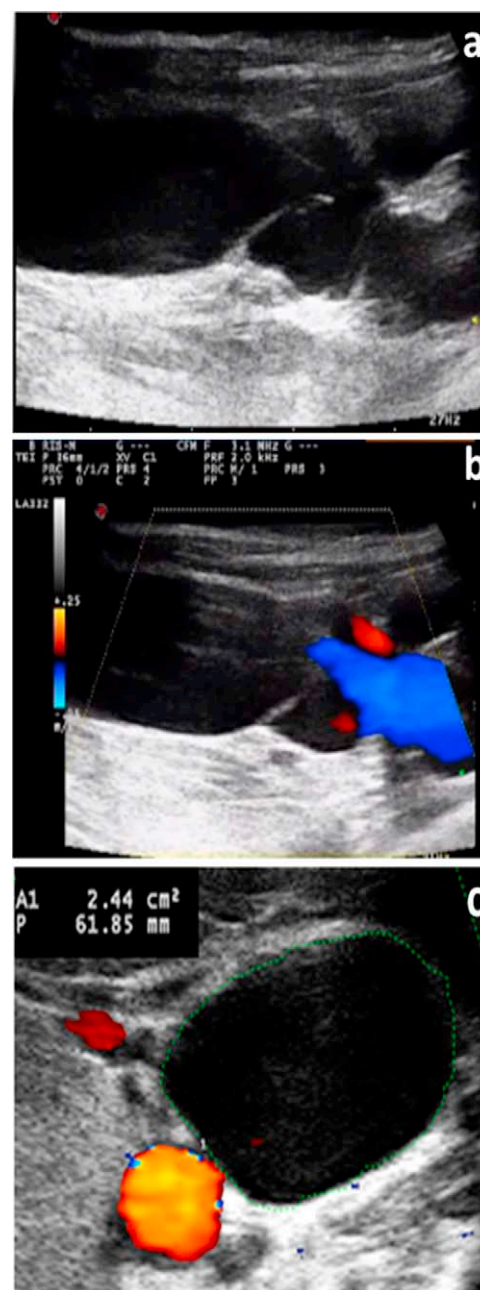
Example of the positivity of criterion 3. (a) B-mode ultrasound examination of the IJV in longitudinal scan. (b) Color-mode ultrasound examination of the IJV in longitudinal scan. (c) CSA measurement at J2 IJV level in transverse scan.
